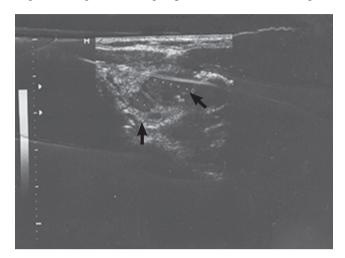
Thyroid ultrasonography result of patient V-5 (from family Iranian 3) with multinodular goiter. The arrows show nodules. The view is axial, and ultrasound probe is positioned in the neck region.
